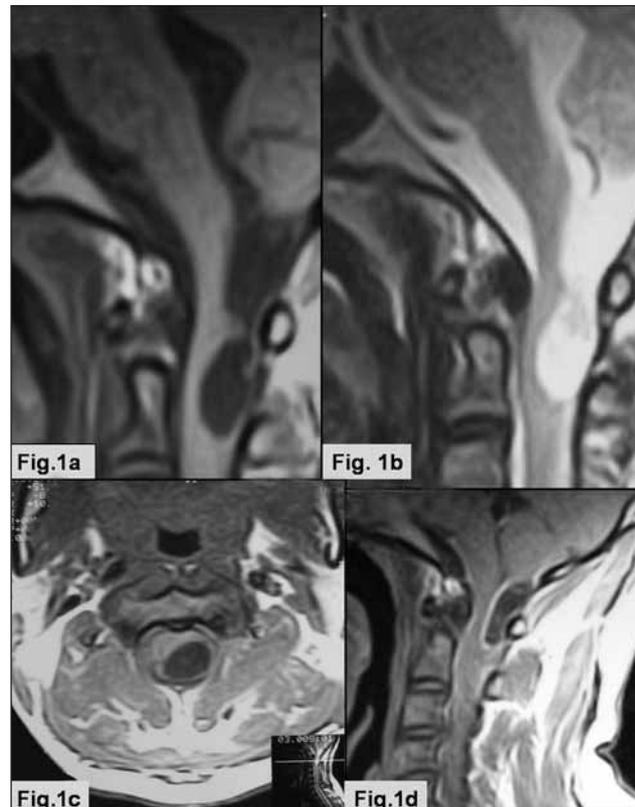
Sagittal T1W (Fig. 1a), Sagittal T2W (Fig. 1b) and axial T1W (Fig. 1c) MR image showing a relatively well defined intradural extramedullary lesion hypointense on T1WI and hyperintense on T2WI with peripheral enhancement on contrast administration (Fig. 1d).
